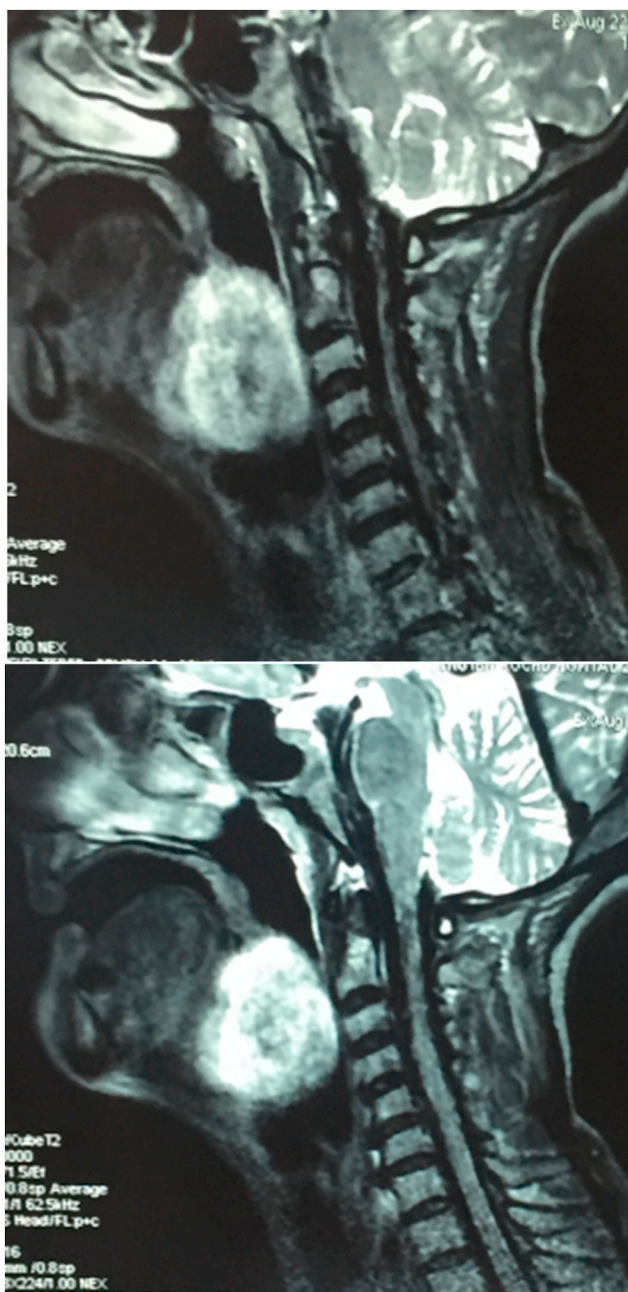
Sagittal T2-weighted MRI images showing the tumor, which is hyperintense, in the tongue base.
